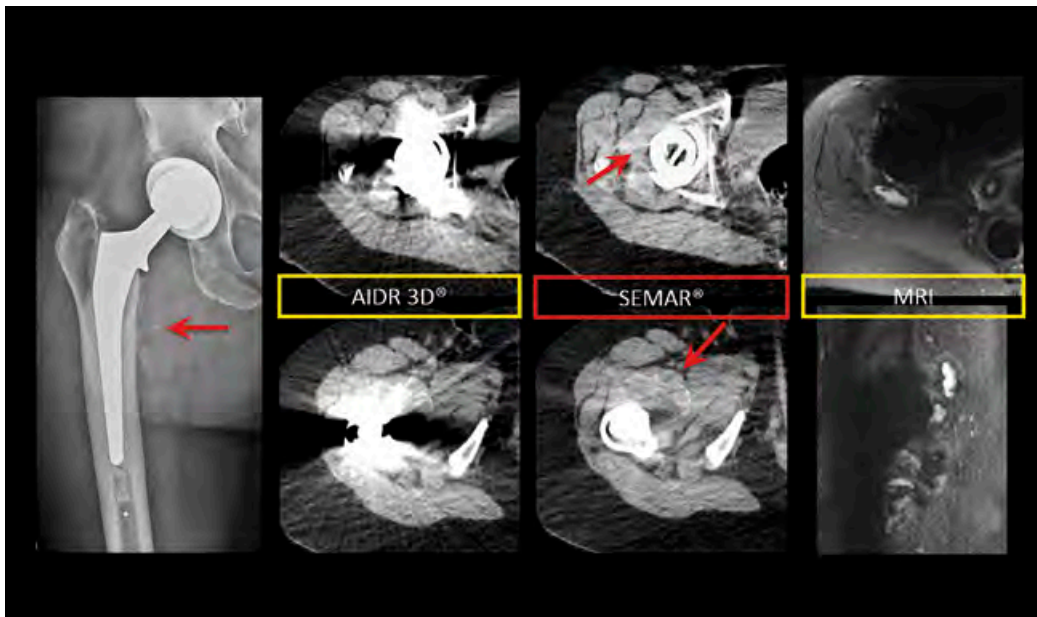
68 year old female patient with painful right Metal-on-Metal THA. Left: FBP, Center: SEMAR, Right: MRI. Acquisition technique: 320 x 0.5 mm, 120 kVp, 100 mAs. Effective dose = 1.2 mSv. Note the when SEMAR is used two peri articular masses became visible (red arrows). Even with state of the art MAR MR images are still greatly hindered by metallic artifacts in this case.
